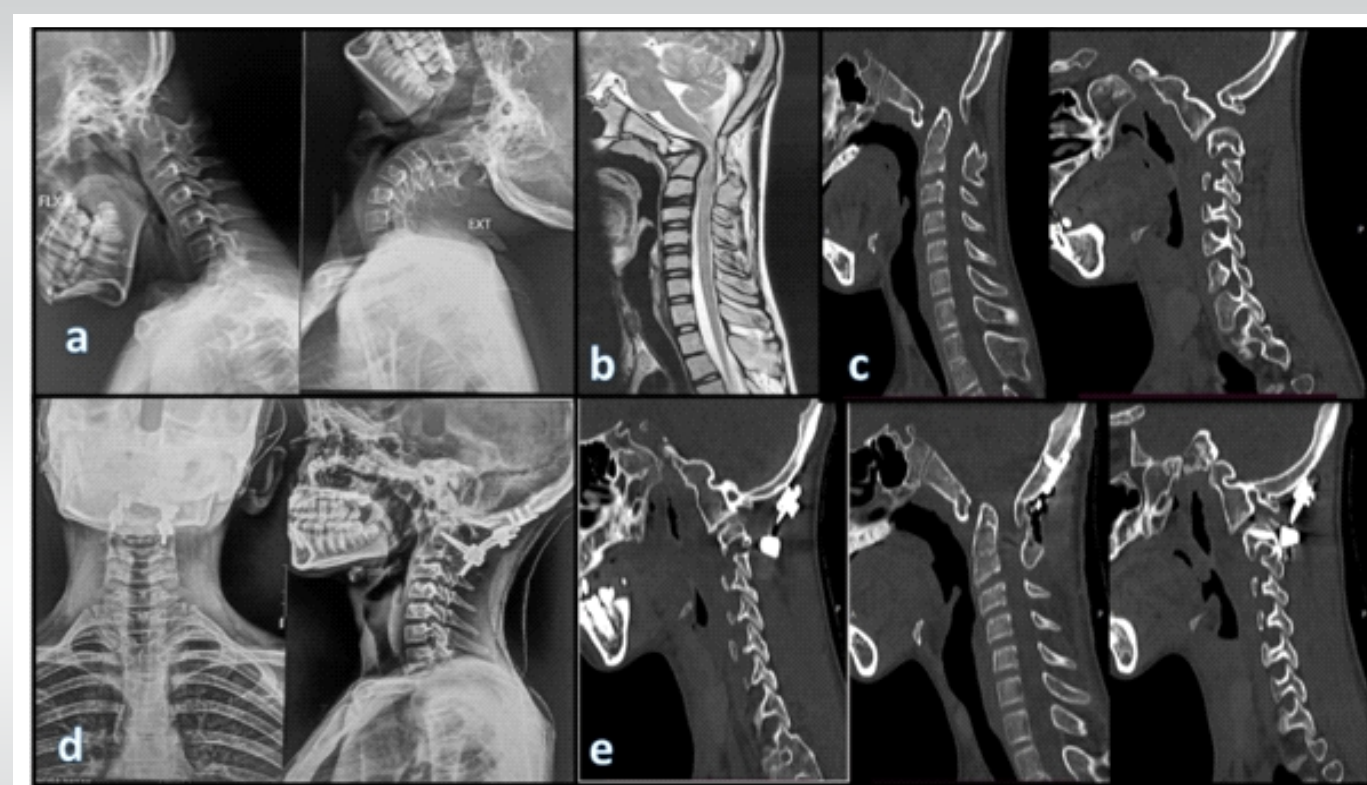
Dynamic Radiographic, CT, and MRI Evaluation Demonstrating Craniovertebral Junction Instability and Postoperative Occipito-Cervical Stabilization (a) Preoperative dynamic flexion-extension cervical radiographs demonstrating significant atlantoaxial instability with abnormal craniovertebral junction mobility and reducibility assessment. (b) Preoperative sagittal magnetic resonance imaging (MRI) showing basilar invagination with severe cervicomedullary compression and ventral indentation at the cervicomedullary junction. (c) Preoperative sagittal computed tomography (CT) images demonstrating superior migration of the odontoid process, atlantoaxial subluxation, and altered clivo-axial alignment consistent with craniovertebral instability. (d) Postoperative anteroposterior and lateral cervical radiographs demonstrating satisfactory occipito-cervical fixation extending from the occiput to C2 with restoration of craniocervical alignment following posterior stabilization. (e) Postoperative sagittal CT images confirming appropriate placement of the occiput-to-C2 fusion construct, adequate decompression at the craniovertebral junction following foramen magnum decompression and C1 posterior arch excision, and improved cervicomedullary alignment.
